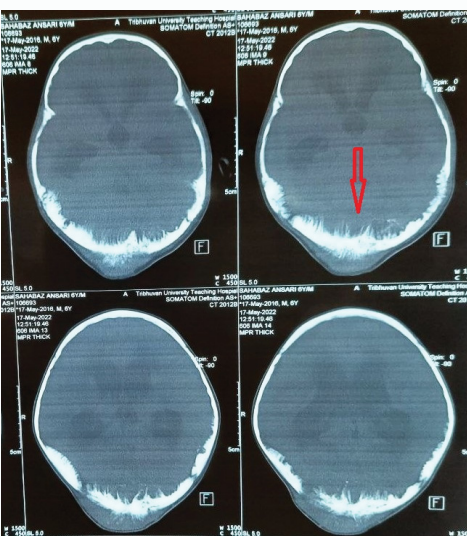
Plain CT head showing lytic sclerotic bony lesion with extensive soft tissue component in the occipital region with extension into intracranial as well as extracranial soft tissue.
